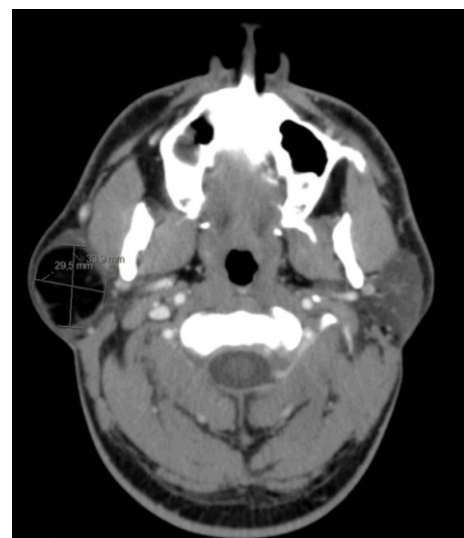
CT scan - Right Parotid Gland Lipoma
